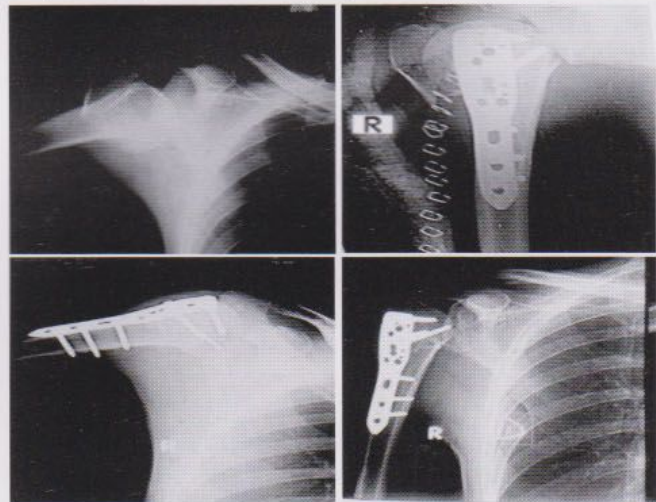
II Pre and post operative x-ray at during follo up
